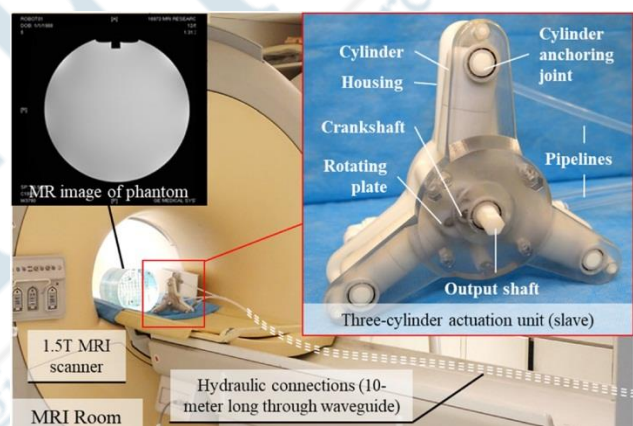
Hydraulic motor setup with three cylinders in a 1.5 T MRI scanner [33].
